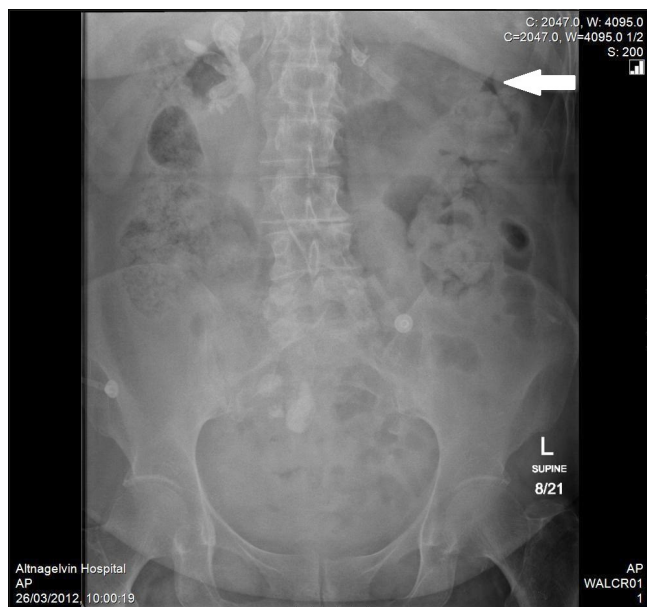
Supine anteroposterior abdominal radiograph showing faecal loading of the colon. A small triangular pocket of free air is evident in the right upper quadrant suggestive of pneumoperitoneum (arrowed).
